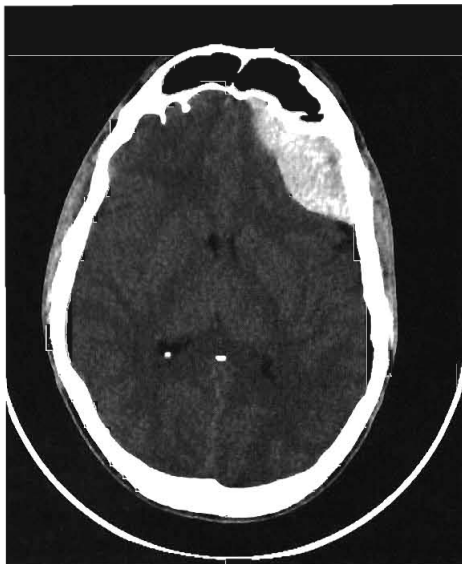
Epidural hematomas have a lens shape and a smooth inner border because they strip the dura from the inner table of the skull as they enlarge (axial CT scan).
